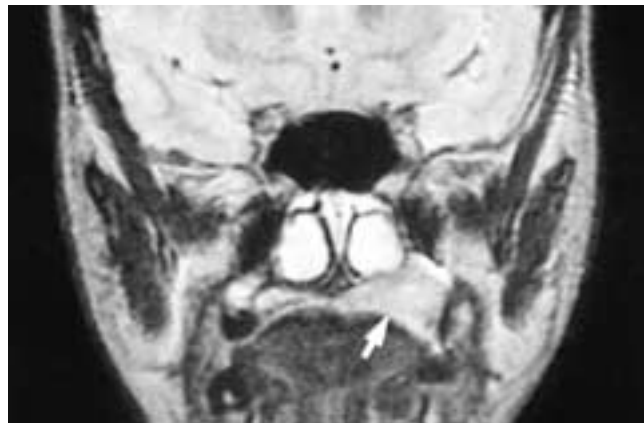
Coronal proton density MR image shows a mass (*arrow*) in the left palate with extension to the lower left antrum. This patient had a high-grade mucoepidermoid carcinoma.
